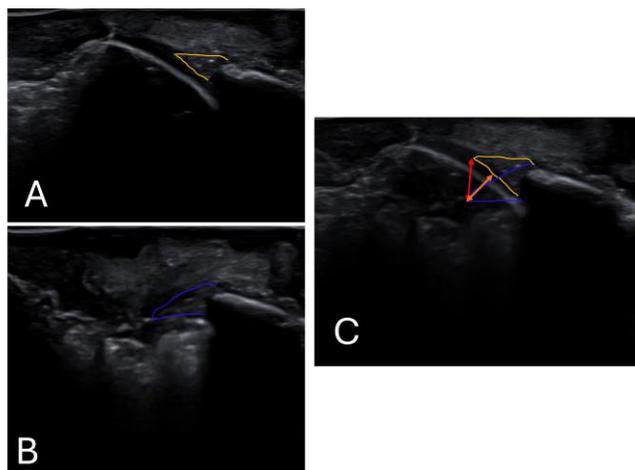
Ultrasound images of acetabular labrum in head-neck junction overresection state A) femur in full extension, labrum noted in yellow tracing; B) femur in flexion with labrum outlined in blue; C) TrakEM2 aligned overlay of extension and flexion images with maximum labrum tip displacement (red) and radial labrum tip displacement (orange)
